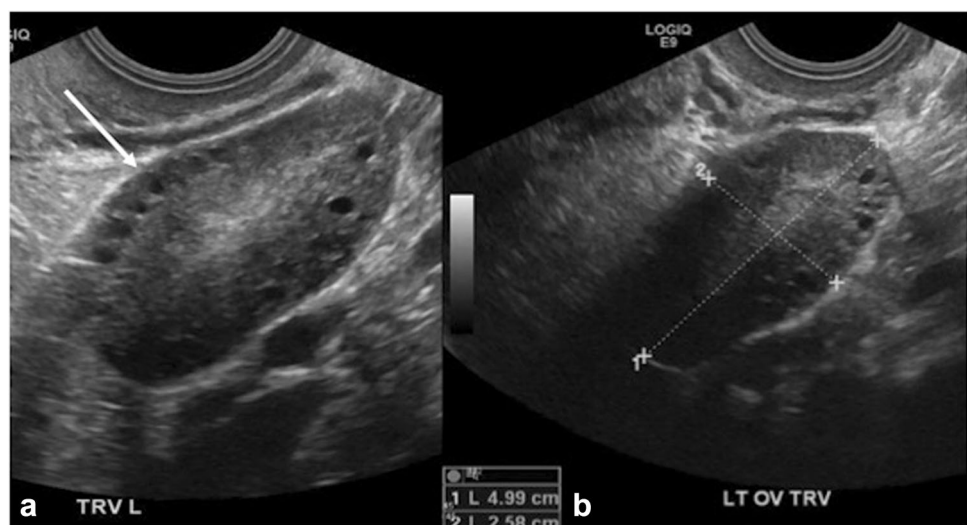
a Transabdominal ultrasound of a pregnant patient at 14 weeks of gestation shows enlarged left ovary with multiple anechoic cysts. b Follow-up at 30 weeks of gestation shows resolution of the cysts with normal size and appearance of the left ovary. c Coronal contrast-enhanced CT of a different patient with complete hydatidiform molar pregnancy shows enlarged bilateral ovaries with multiple enlarged cysts
